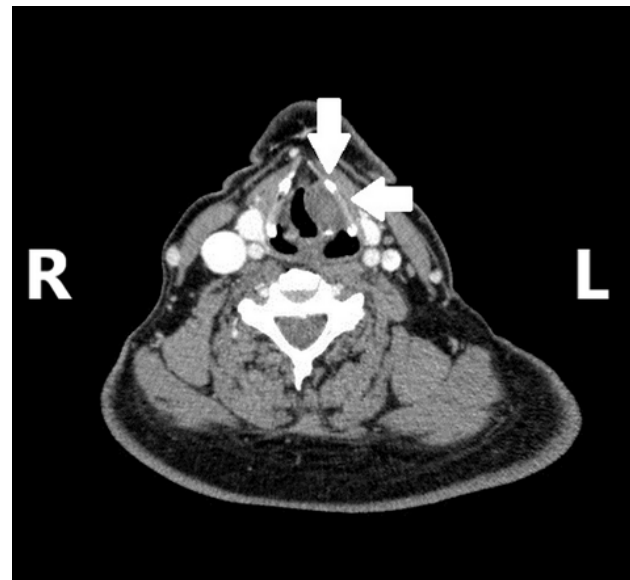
Multislice computed tomography showing an oval, well defined, heterodense mass in the region of the left ventricular fold, extending toward the left vocal fold and posterior commissure of the larynx, with signs of initial destruction of the thyroid cartilage.
